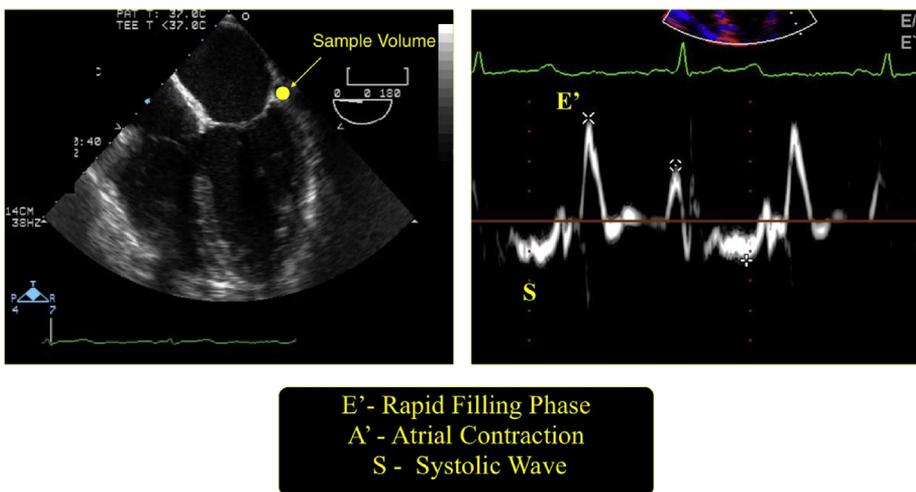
Spectral tissue Doppler display. Left panel, Mid-esophageal 4-chamber view showing the correct placement of the pulsed wave Doppler. Right panel, actual wave pattern of TDI showing measured velocities. E' = rapid relaxation wave, A' = atrial systolic wave, S = ventricular systolic wave.
